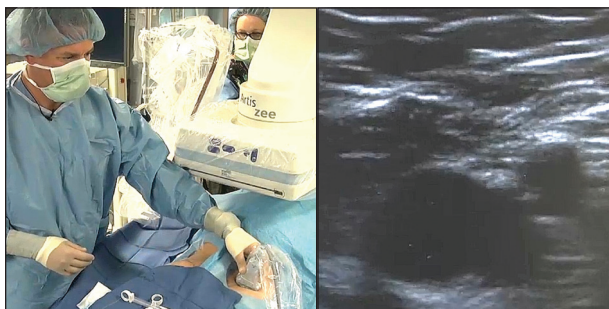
Hand-held ultrasound imaging of the left common femoral artery. All of the required equipment is arranged and organized on the sterile drape. The inset ultrasound image shows the bifurcation of the profunda.
